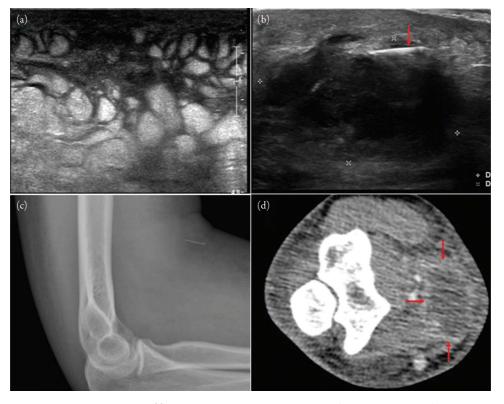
Abscess of the antecubital fossa. Panel (a) shows a grayscale ultrasound image of the proximal volar forearm in the transverse plane with ill-defined heterogeneous echogenicity of the subcutaneous soft tissues in a cobblestone pattern representing edema or inflammation. No focal drainable collection is seen. In Panel (b), a more well-defined hypoechoic soft tissue mass is seen proximal to the previously described edema. This abscess is adjacent to a retained linear foreign body (arrow). No flow is seen in the central portion of this mass with color Doppler (not shown). Panel (c) is an elbow radiograph showing the retained needle fragment. Panel (d) is an axial computed tomography image of the elbow after IV contrast showing a peripherally enhancing low-density structure (between arrows) corresponding to the presumed abscess seen on the ultrasound.
